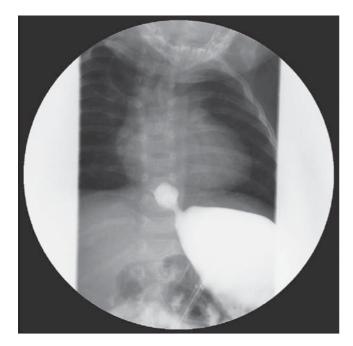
A radiograph obtained at 3 months of age at our hospital shows a dilated proximal esophageal pouch with air in the upper-right-side thoracic and distal esophagus. Long gap esophageal atresia type A was revealed. A thoracic second and third vertebral anomaly was demonstrated
